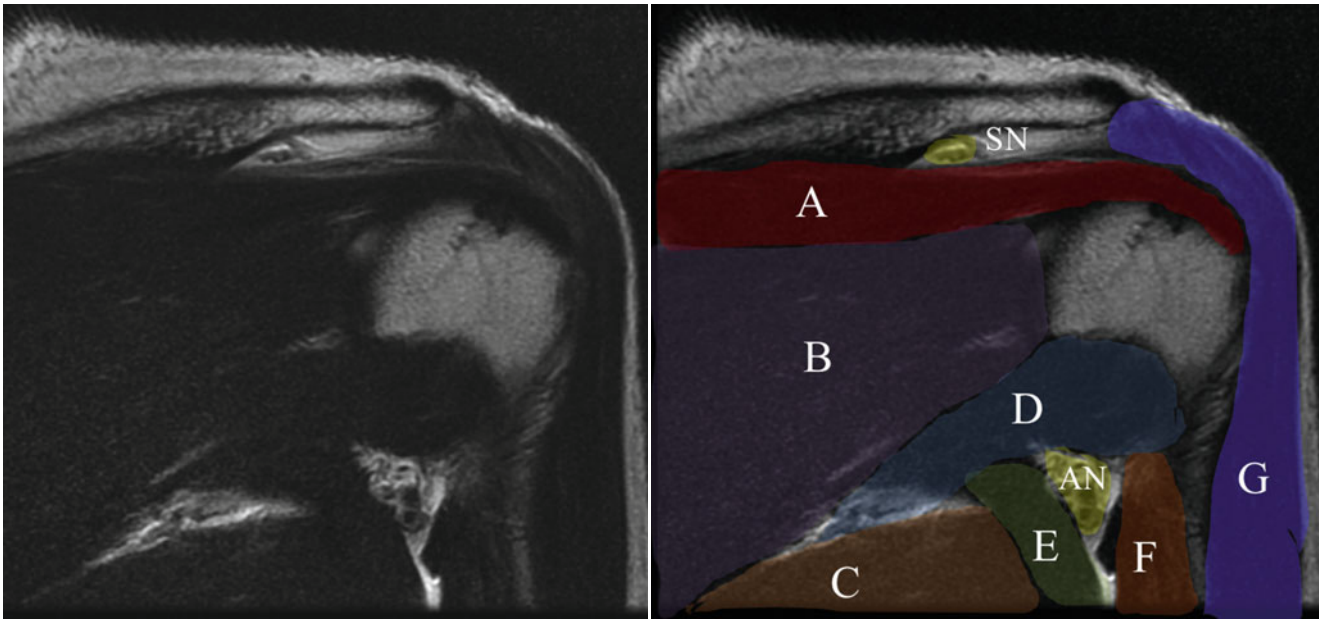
Labeled MRI of the shoulder. *SN* suprascapular nerve, *AN* axillary nerve and axillary vessels, *A* supraspinatus muscle, *B* infraspinatus muscle, *C* teres major, *D* teres minor, *E* long head of the triceps
